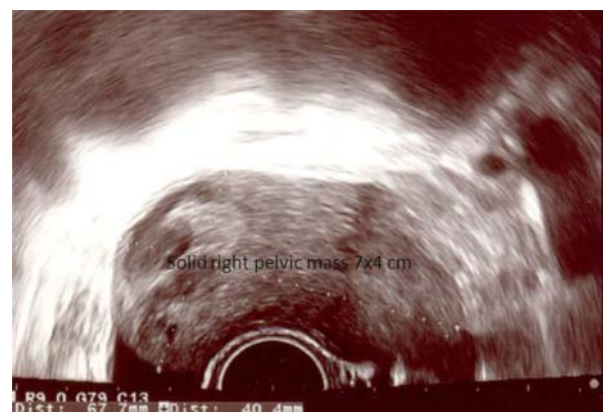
Ultrasonography showing a solid right pelvic mass with some irregular internal echogenicity.
